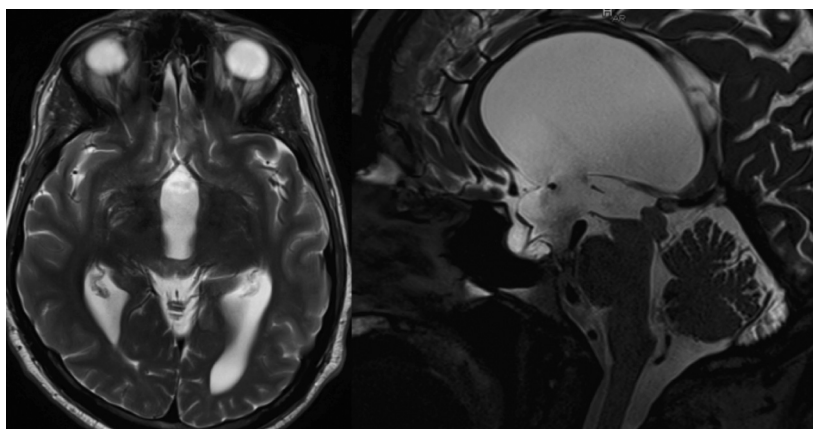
MRI sequences axial/sagittal before ETV showing aqueductal stenosis and subsequent hydrocephalus.
